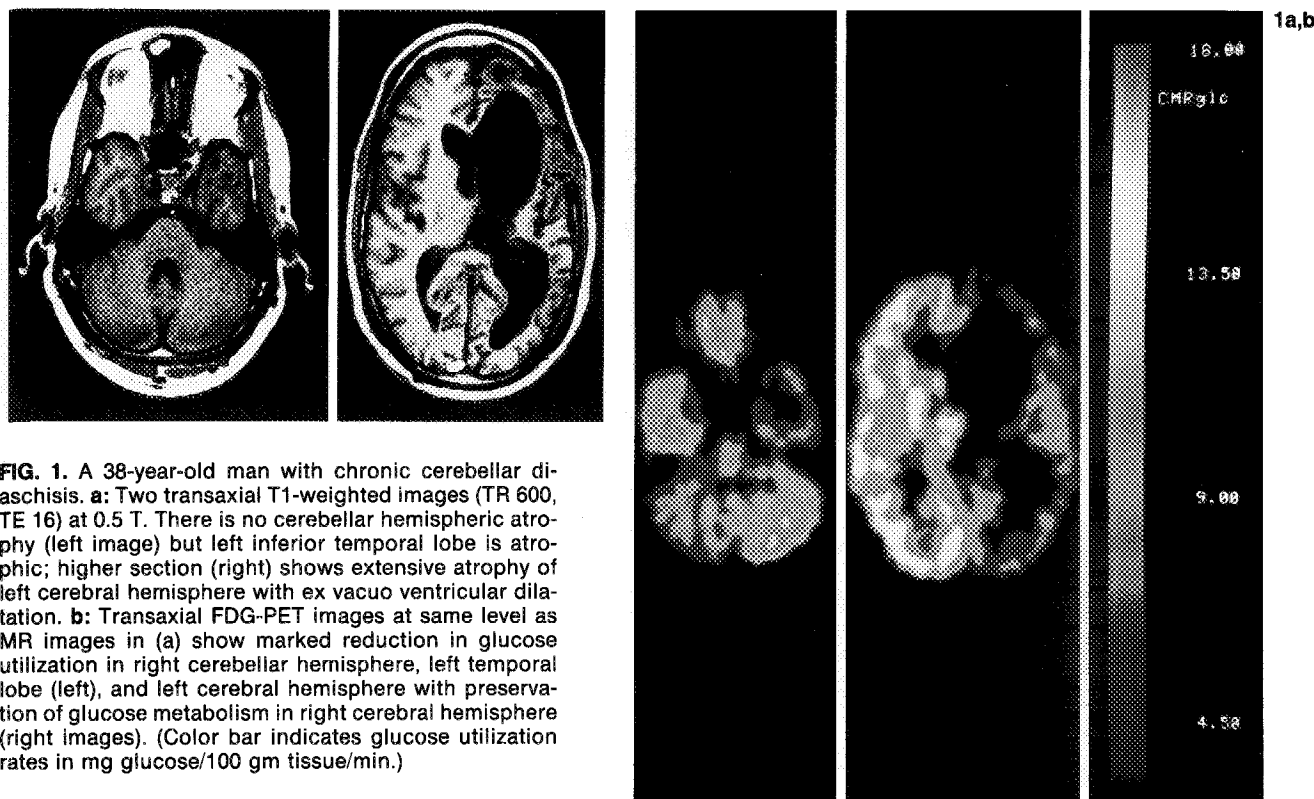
A 38-year-old man with chronic cerebellar diaschisis. a: Two transaxial T1-weighted images (TR 600, TE 16) at 0.5 T. There is no cerebellar hemispheric atrophy (left image) but left inferior temporal lobe is atrophic; higher section (right) shows extensive atrophy of left cerebral hemisphere with ex vacuo ventricular dilatation. b: Transaxial FDG-PET images at same level as MR images in (a) show marked reduction in glucose utilization in right cerebellar hemisphere, left temporal lobe (left), and left cerebral hemisphere with preservation of glucose metabolism in right cerebral hemisphere (right images). (Color bar indicates glucose utilization rates in mg glucose/100 gm tissue/min.)
